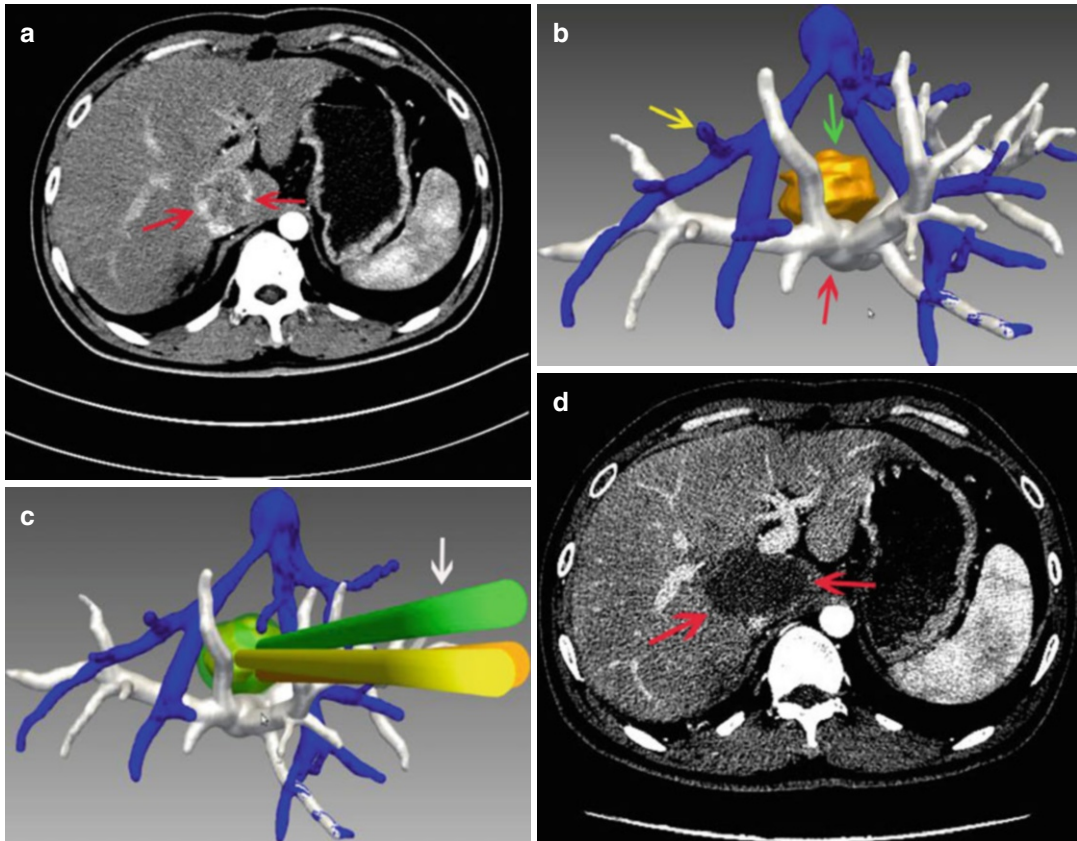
Images in a 45-year-old patient with a tumor in the caudate lobe. (a) Preoperative CT image showed that the tumor (red arrows) was close to portal vein. (b) The 3D visualization images visualized the spatial relationship of tumor and the surrounding pipe in multi-angle. (yellow arrow: hepatic vein; green arrow: tumor; red arrow: portal vein) (c) The preoperative planning was achieved through 3D visualization of preoperative planning system, and three needles (white arrow) were needed to ablate the tumor completely. (d) The contrast-enhanced CT showed complete tumor necrosis (red arrows) a month after microwave ablation (MWA)
